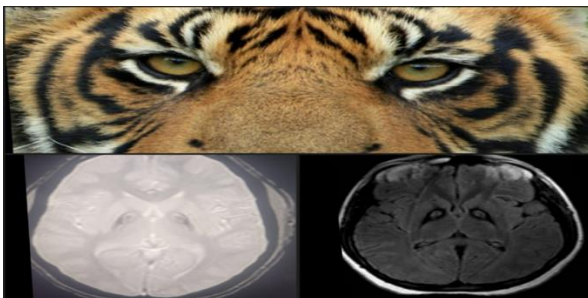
“Eye-of-the-tiger” sign—central hyperintensity within the globus pallidus on T2-weighted MRI.
